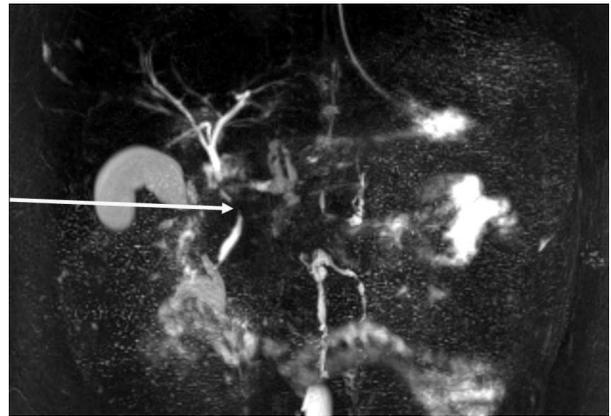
MRI showing main biliary duct narrowed by venous network called portal cavernoma (arrow).
